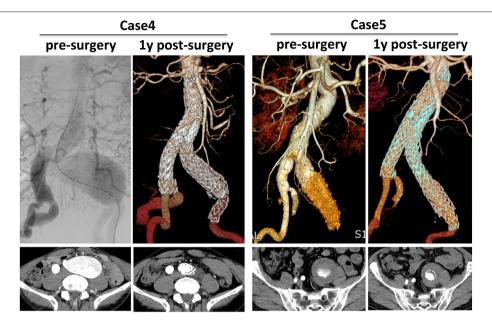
Typical cases of CST for isolated iliac aneurysms. 3D CTA pre-surgery and 1-year post-surgery was compared and corresponding transverse section was also presented.
